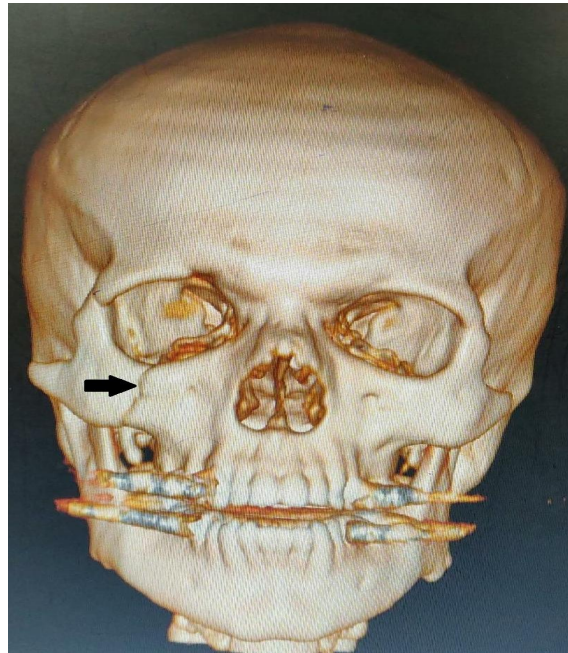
Three-dimensional reconstruction of computed tomography reveals fracture of right zygoma
